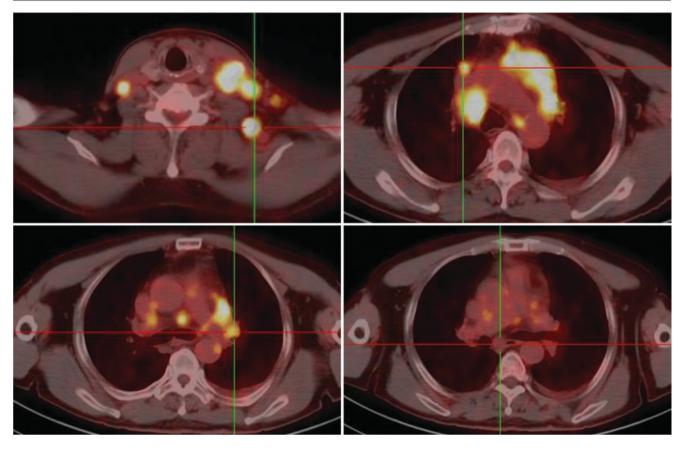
PET-CT of a 59-year-old man was found to have enlarged left cervical lymph nodes for 12 days
